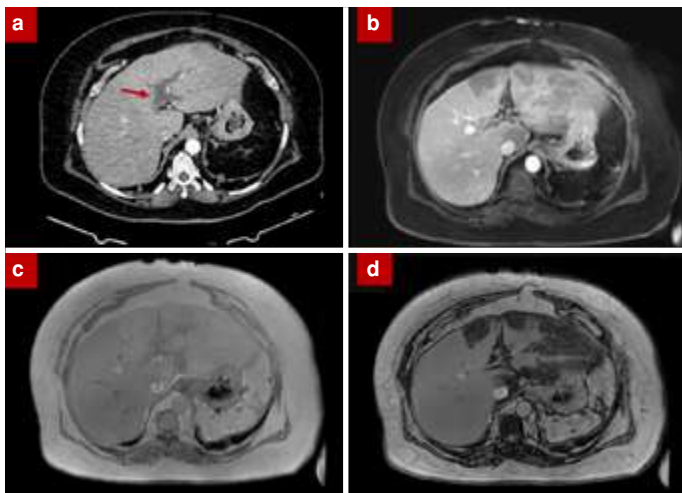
CT imaging demonstrates left portal vein thrombosis (arrow) (a). MR images (b–d) reveal patchy, nonenhancing areas (b), observed on dual-echo in-phase images (c), corresponding to focal fatty infiltration in the left liver lobe, confirmed by out-of-phase imaging (d).
